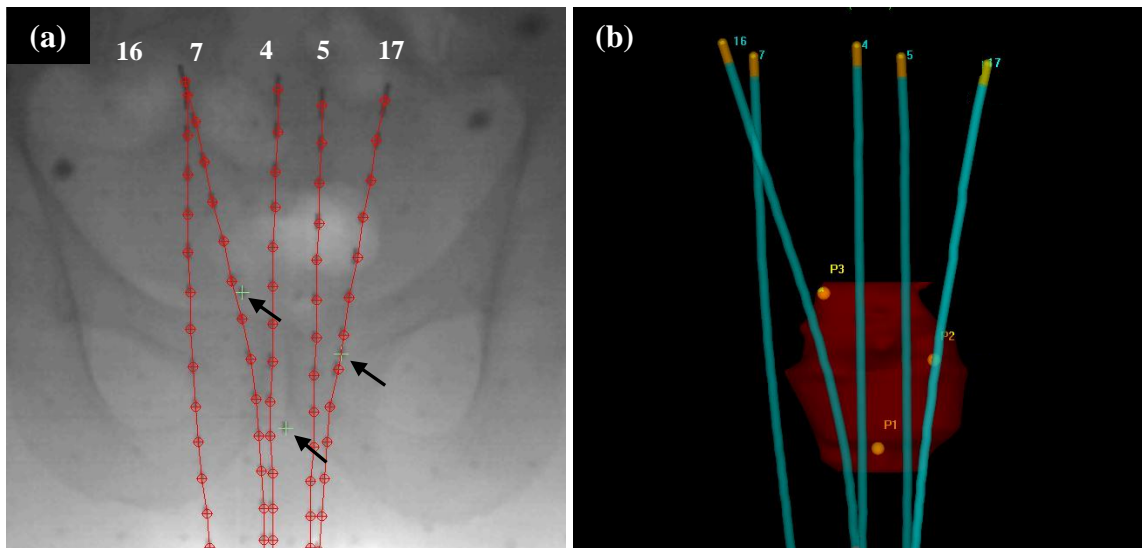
(a) The measured catheter paths are identified in red along with the 3 fiducial markers (green crosses). (b) For comparison with the A-P image, the TPS A-P view of the implant showing the catheters used for pre-treatment imaging and the 3 fiducial markers identified in the CT data.
